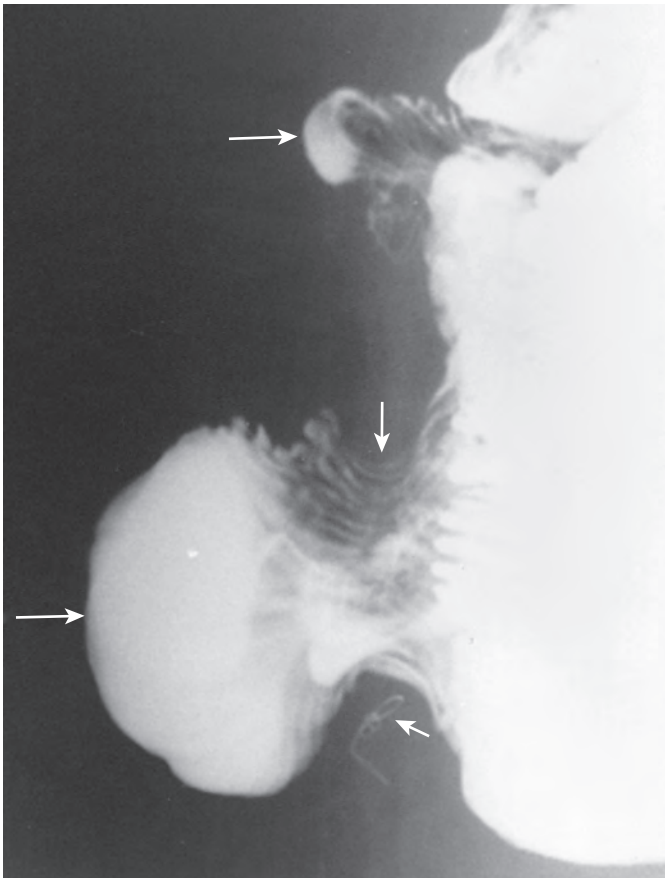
Incisional hernias detected on lateral view. Spot radiograph from small bowel follow-through shows intestinal loops (*large arrows*) protruding through the expected location of the anterior abdominal wall (identified by wire sutures, *small arrow*). Mild, smooth compression of the lower loop with preservation of normal folds (*mid-sized arrow*) is present at the neck of the lower hernia sac.
